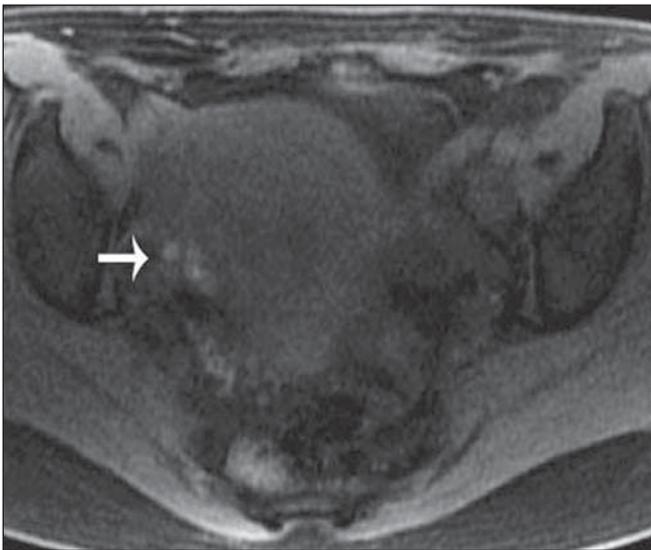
Ovarian focus of endometriosis. Axial MRI T1-weighted fat-sat image acquired with a 1.5 T scanner, demonstrating a focus of hypersignal intensity on the right ovary.
